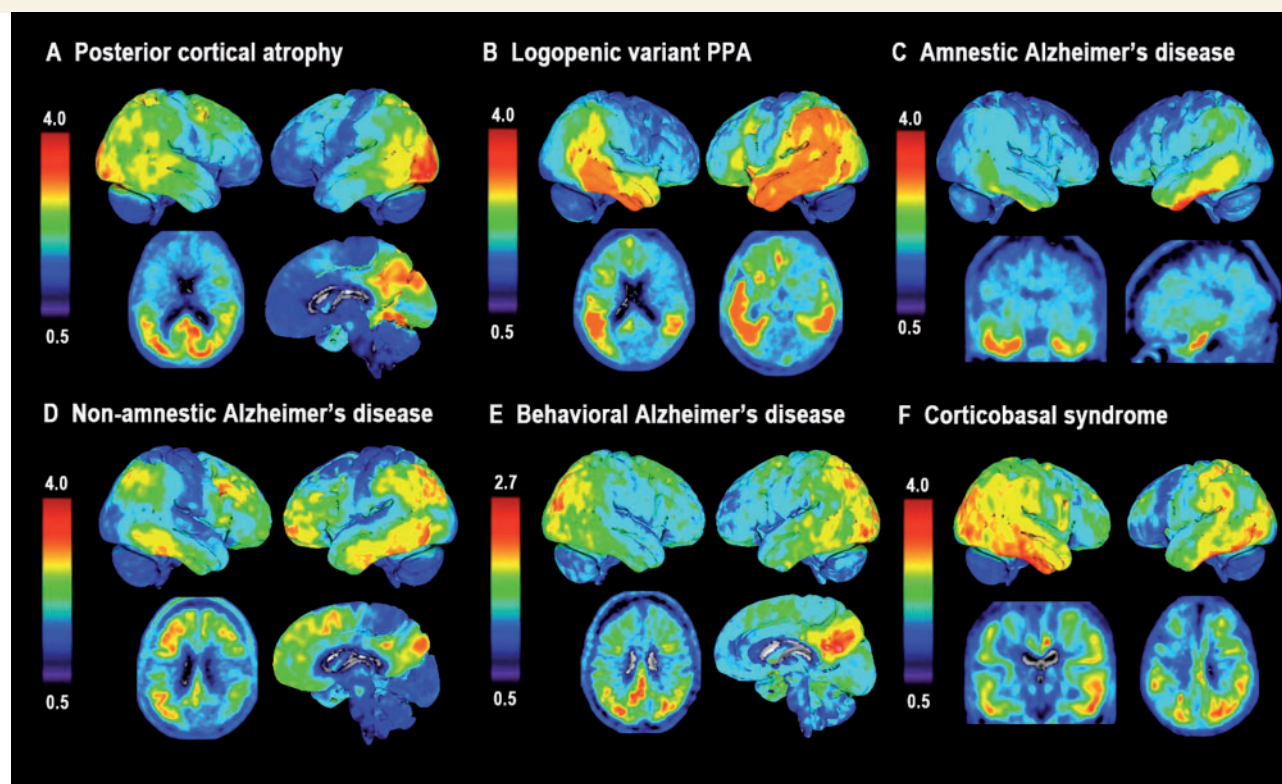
^{18}F -AV1451 uptake in individuals with distinct phenotypes of Alzheimer's disease. SUVR ^{18}F -AV1451 images (neurological orientation) in (A) a 59-year-old female (MMSE: 28) with posterior cortical atrophy [note that this is a different patient than presented in Ossenkoppele *et al.* (2015d)]; (B) a 77-year-old female (MMSE: 17) with logopenic variant PPA; (C) a 71-year-old female (MMSE: 23) with amnesic Alzheimer's disease; (D) a 59-year-old female (MMSE: 27) with non-amnesic Alzheimer's disease; (E) a 59-year-old male (MMSE: 21) with a behavioural presentation of Alzheimer's disease, and (F) a 60-year-old female (MMSE: 16) with a corticobasal syndrome affecting the left hemisphere.
